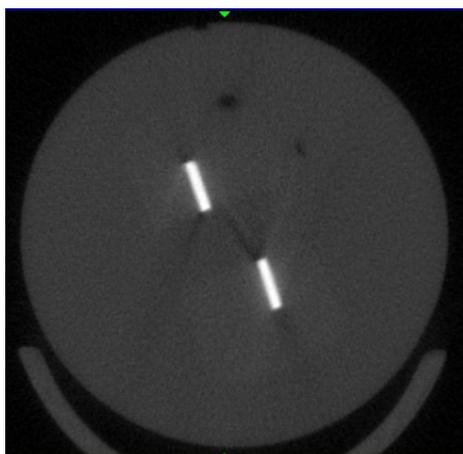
Image test for slice thickness in micro CT without Iomeron 400.
